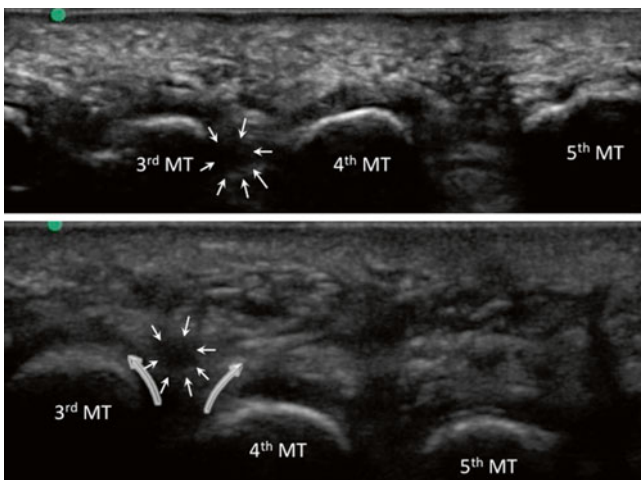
Sonography of the Morton's neuroma. Short axis view of the forefoot when the ultrasound probe was applied over the metatarsal heads on the plantar surface of the foot. The upper figure showed the neuroma (*line arrows*) as a hypoechoic structure between the 3rd and 4th metatarsals (MT) at the resting state. On squeezing the metatarsal heads together (Mulder test), the neuroma was squeezed out of the metatarsal heads (Reproduced with permission from Philip Peng Educational Series)
